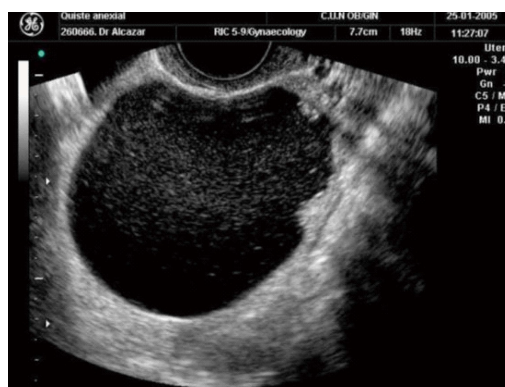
Transvaginal ultrasound showing a lesion that should not be considered as simple cyst, since papillary projection can be seen arising from the wall.
